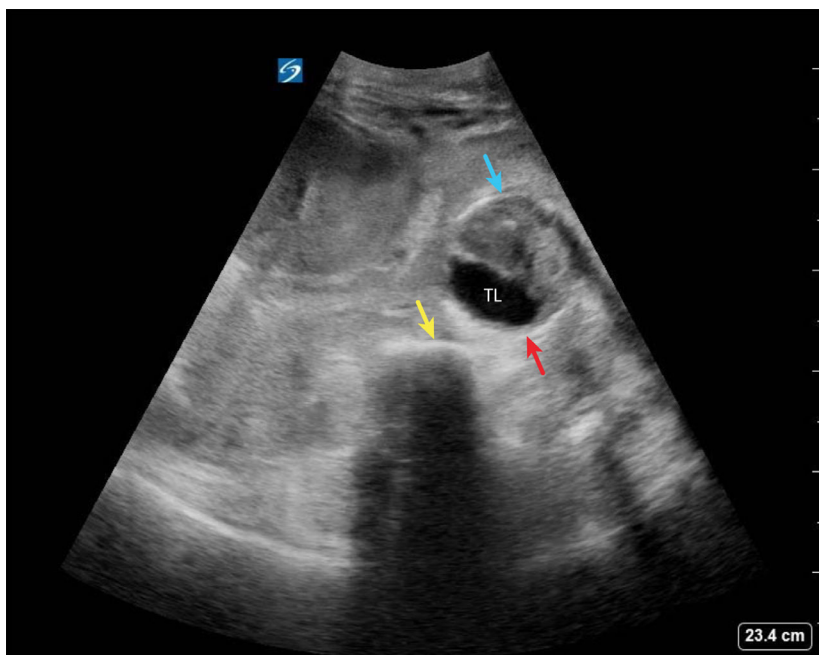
Bedside ultrasonography displays extensive hemoperitoneum and an aneurysmal infrarenal abdominal aorta with extensive intramural hematoma, indicating an aneurysmal abdominal aorta with rupture (TL, true lumen; blue arrow, anterior wall of abdominal aorta; red arrow, posterior wall of abdominal aorta; yellow arrow, anterior aspect of the spine/vertebral body)
